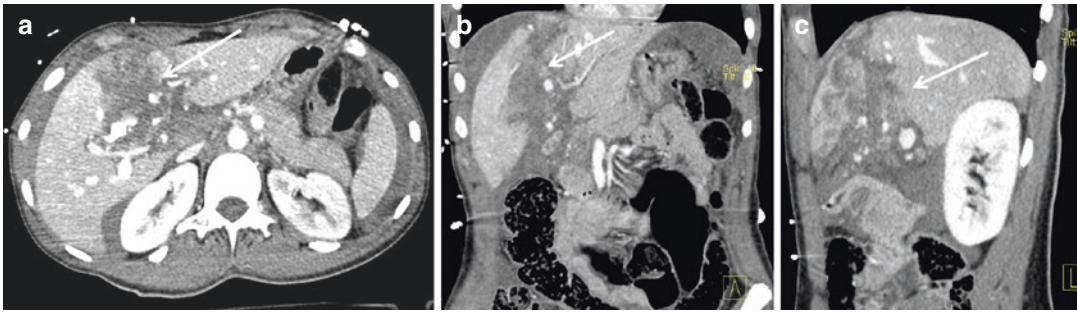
(a) Axial CT scan, (b) coronal, and (c) sagittal reconstruction show a IV grade parenchymal lesion, involving segment IV completely
